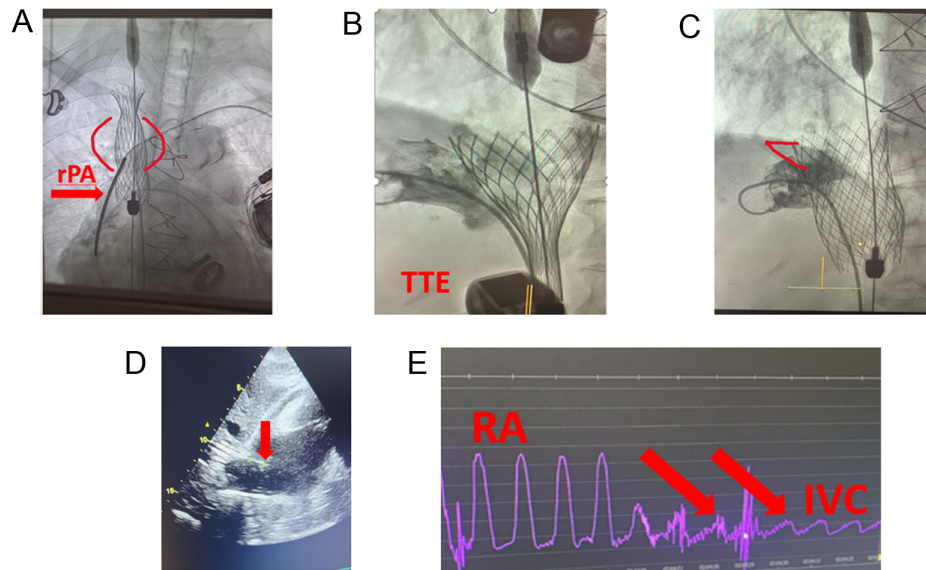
Echocardiographic and fluoroscopic images from different stages of the procedure. (A) Deployment of the SVC valve by aligning it. The belly part of the device is positioned over the catheter placed in the rPA. (B) Alignment of the IVC valve by both TTE and hepatic venography. (C) Right atrial protrusion of the IVC device observed on scopy. (D) A subcostal image on TTE showing the measurement of the device protruding into the right atrium. (E) Pressure recording demonstrating a significant difference between the RA and IVC, indicating procedural success.
